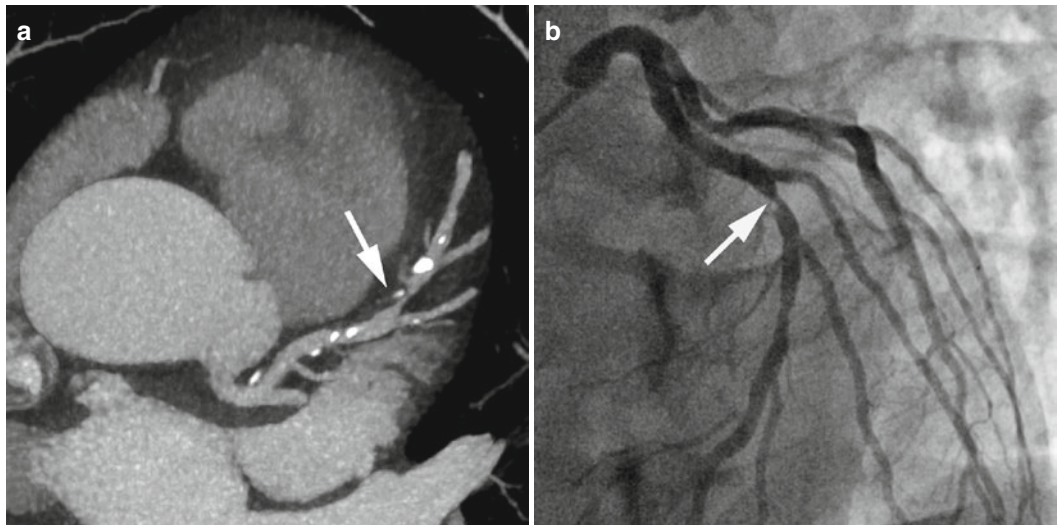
Severe stenosis of the left anterior descending coronary artery proximal to the bifurcation to the first diagonal branch (*arrow*), Medina Classification 1/0/0. (a) Coronary CT angiography. (b) Invasive coronary angiography
